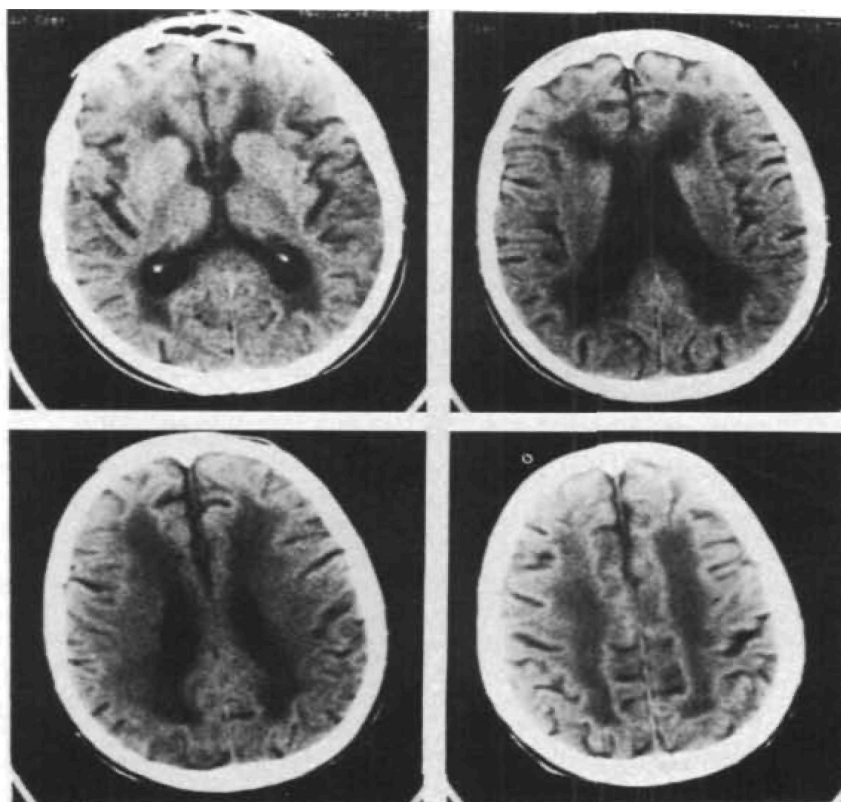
CT scan shows peri ventricular and Centrum semiovale low density with enlarged ventricles and widened sulci
